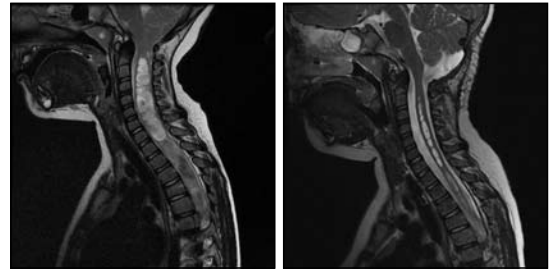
Left panel, Preoperative sagittal T2 cervical spine MRI showing Chiari malformation and syringomyelia with expansion of the spinal cord. Right panel, Postoperative MRI showing surgical changes of suboccipital craniectomy, C1 laminectomy with duroplasty resulting in enlargement of the space around the cerebellar tonsils, and reduction in the syringomyelia.
